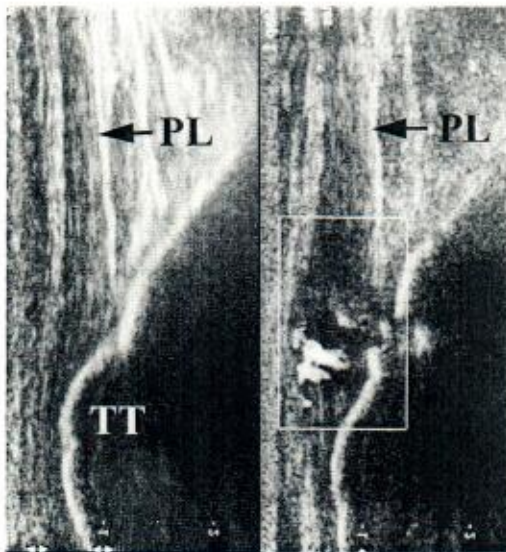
Ultrasonography of the anterior aspect of the tibial tuberosity (TT) and patellar ligament (PL) in the normal knee (left) of the same patient as in Fig. 13.51. The avulsion with its osseous defect is visualized (right) with loss of normal structures of the patellar ligament and Doppler enhancement distal to the avulsion
